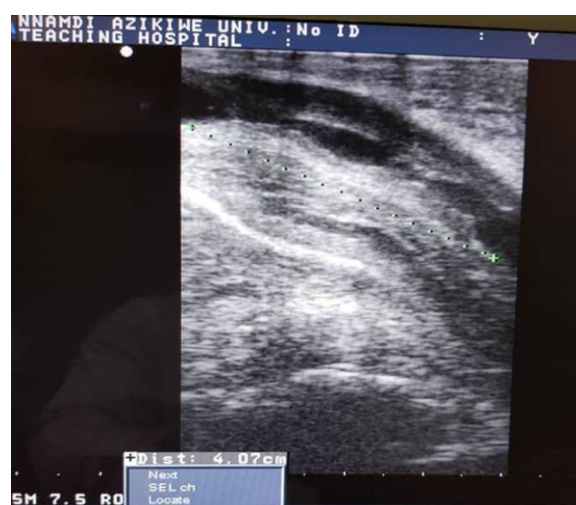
Sonogram showing long segment anterior urethral stricture
